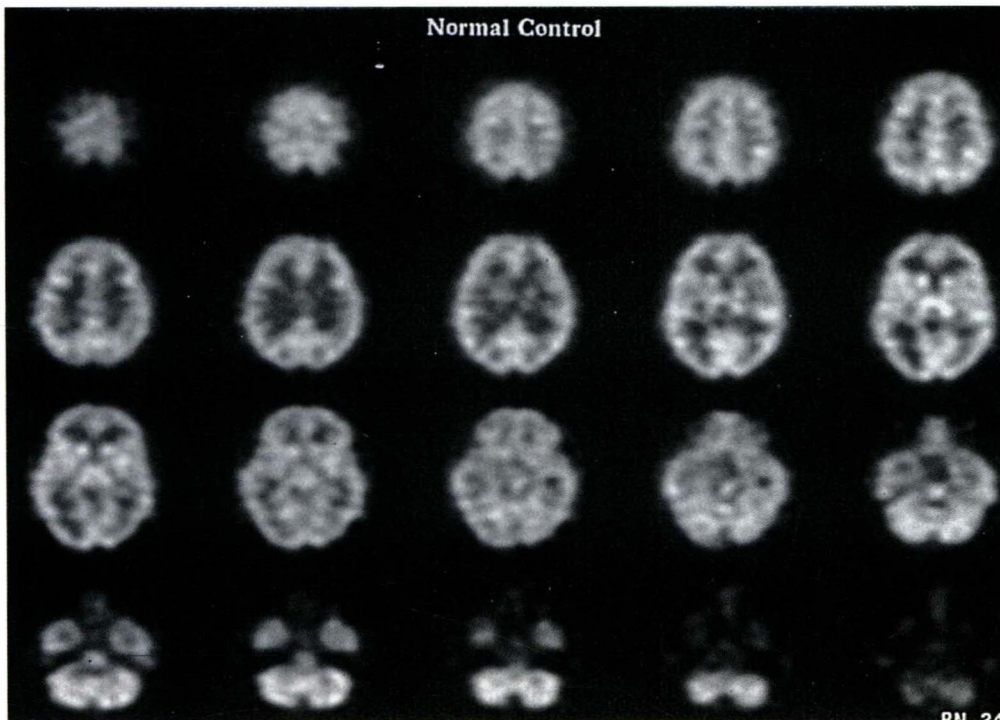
Typical high-resolution rCBF SPECT images obtained using ^{99m}Tc -HMPAO and the PRISM 3000S tomograph in a normal volunteer.
